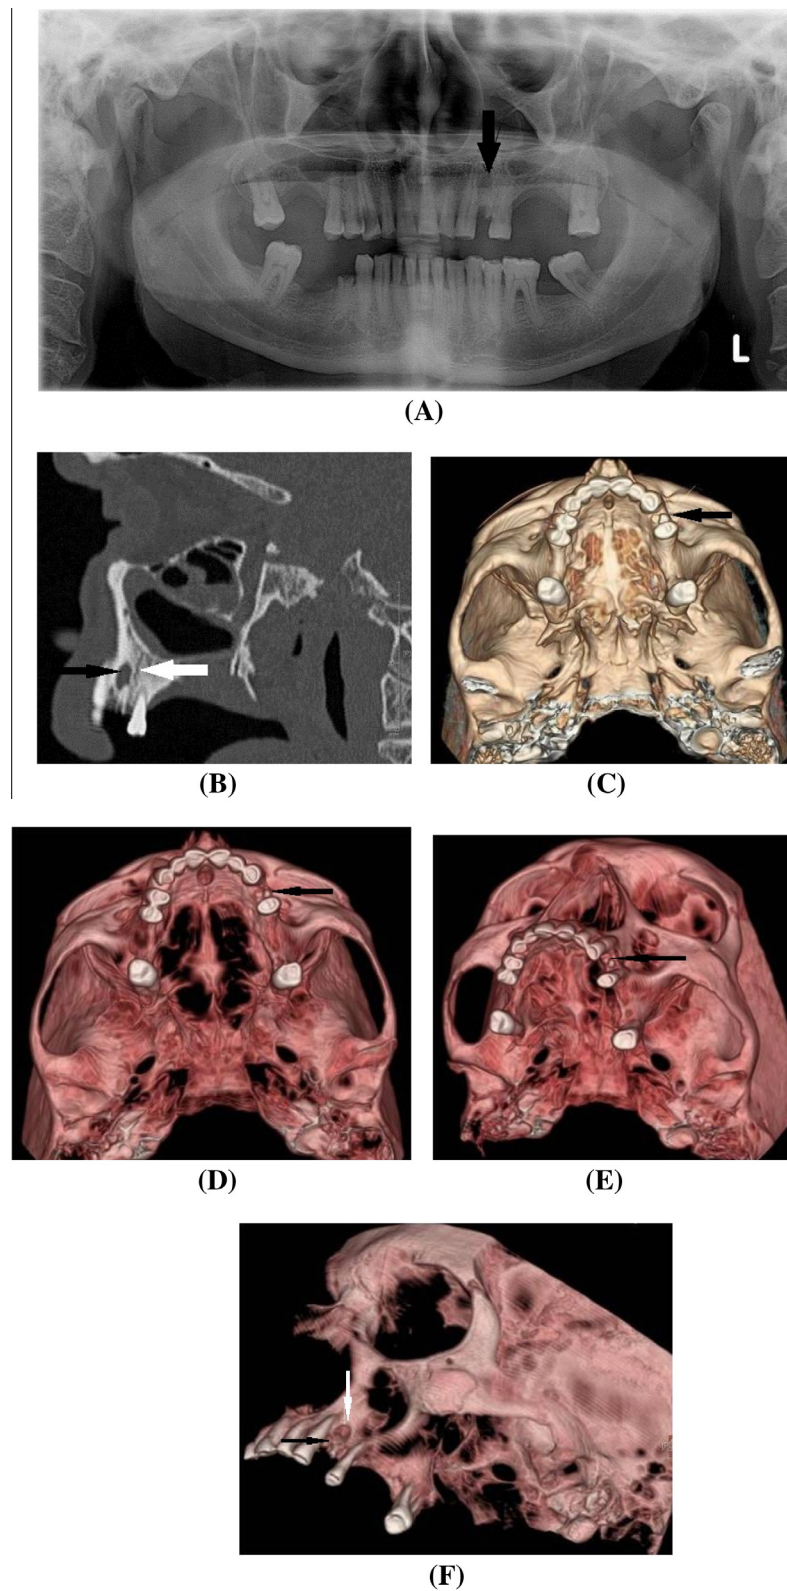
A case of periapical abscess surrounding the retained root of the left maxillary first premolar tooth. The tooth is broken and the crown is lost. Fissure fracture is noted crossing the alveolar process of the maxilla just posterior (distal) to the abscess, the fracture line did not violate to the bony plate forming the floor of the maxillary antrum. No oro-antral fistula is noted. (A) Digital Panorama X-ray view: the periapical abscess is adequately noted. This view failed to adequately demonstrate the fracture. (B) Reconstructed sagittal oblique MDCT image in bone window, showing the periapical abscess (black arrow) and fracture line (white arrow). (C–F) The retained roots (black arrows) and the abscess (white arrow) are demonstrated in 3-D VR images using different angles and software.
